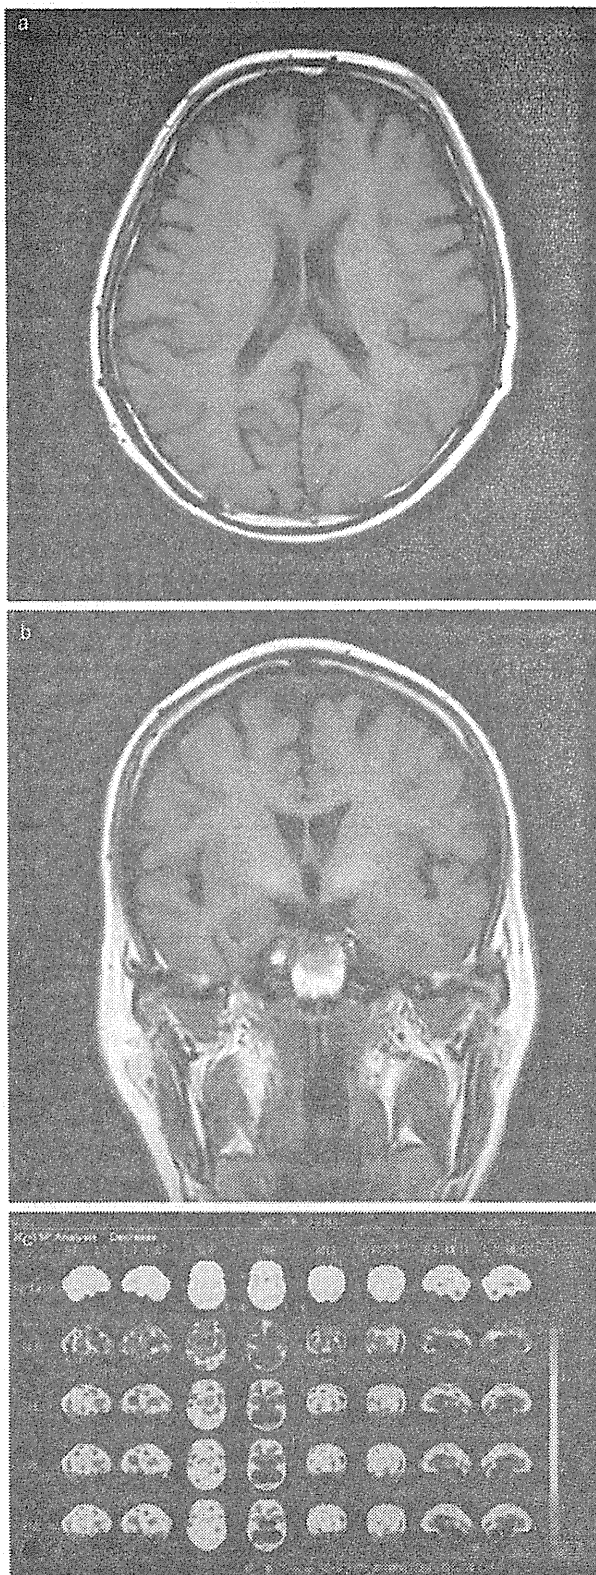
Representative neuroimaging of unclassified behavioral variant of major frontotemporal neurocognitive disorder (bvFT-NCD). (a) Coronal T1-weighted magnetic resonance imaging (MRI). (b) Axial T1-weighted MRI. (c) Single photon emission computed tomography imaging. Images are reconstructed using the three-dimensional stereotactic surface projection (3D-SSP) technique and superimposed on normalized images of standardized brain MRI. Color-coding represents the statistical significance (Z-score) of the decrease in regional cerebral blood flow (rCBF) in the resting mode. Red represents more significant rCBF reduction. From left to right, eight directions of the brain surface images are shown: right lateral (RT.LAT), left lateral (LT.LAT), superior (SUP), inferior (INF), anterior (ANT), posterior (POST), right medial (RT.MED) and left medial (LT.MED). Vertically from the second to the fifth lines, Z-score maps are shown (high Z-score indicates decrease): the Z-score map was normalized to the cerebral global mean (GLB) in the second line, to the thalamus (TH) in the third line, to the cerebellum (CBL) in the fourth line and to the pons (PONS) in the fifth line. The distribution of rCBF is shown in the first line (red color-coding represents increment of rCBF). Neither the cortical atrophy shown in MRI images nor the rCBF reduction pattern of the three-dimensional stereotactic surface projection images is typical for frontotemporal dementia.
